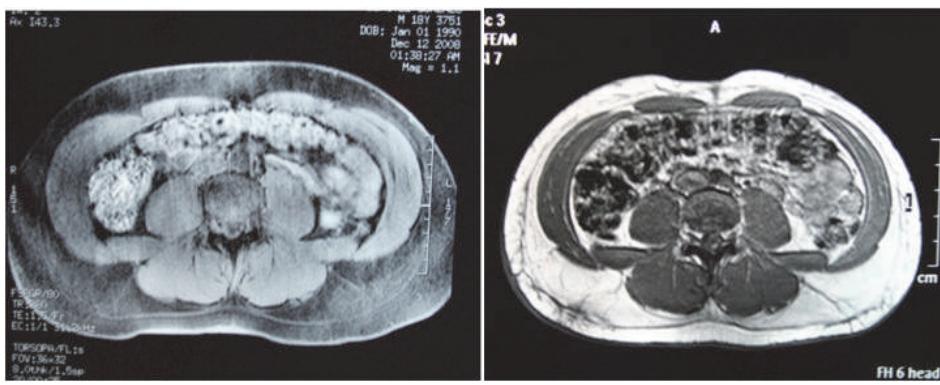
Magnetic resonance imaging of the abdomen before (left) and 3 months after (right) RFAL, showing significant reduction of the abdominal fat thickness and mild edema. Note the indentation of the mid-abdominal line at 3-month follow-up, which was absent prior to the procedure.
